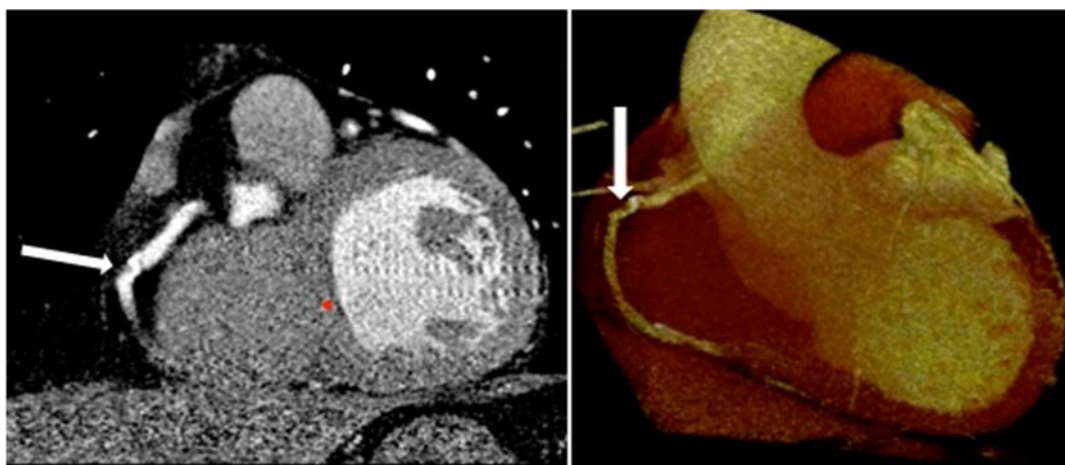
60 year-old symptomatic man. Curved planar reformatted (Left) and volume-rendered (Right) CT angiography images show a noncalcified soft plaque (white arrows), which is causing a significant (65%) stenosis in the RCA
